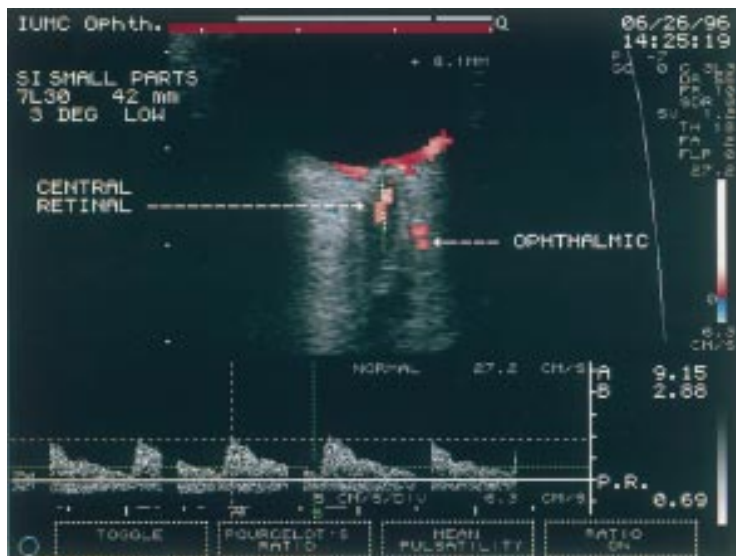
Example of image from colour Doppler imaging of retrobulbar vessels. Shown are coloured pixels from the ophthalmic and central retinal arteries. The Doppler frequency spectrum for the central retinal artery is shown as the wave form at the bottom of the picture. The corresponding peak systolic velocity, end diastolic velocity, and resistance index as determined from the wave form are shown on the bottom right.
